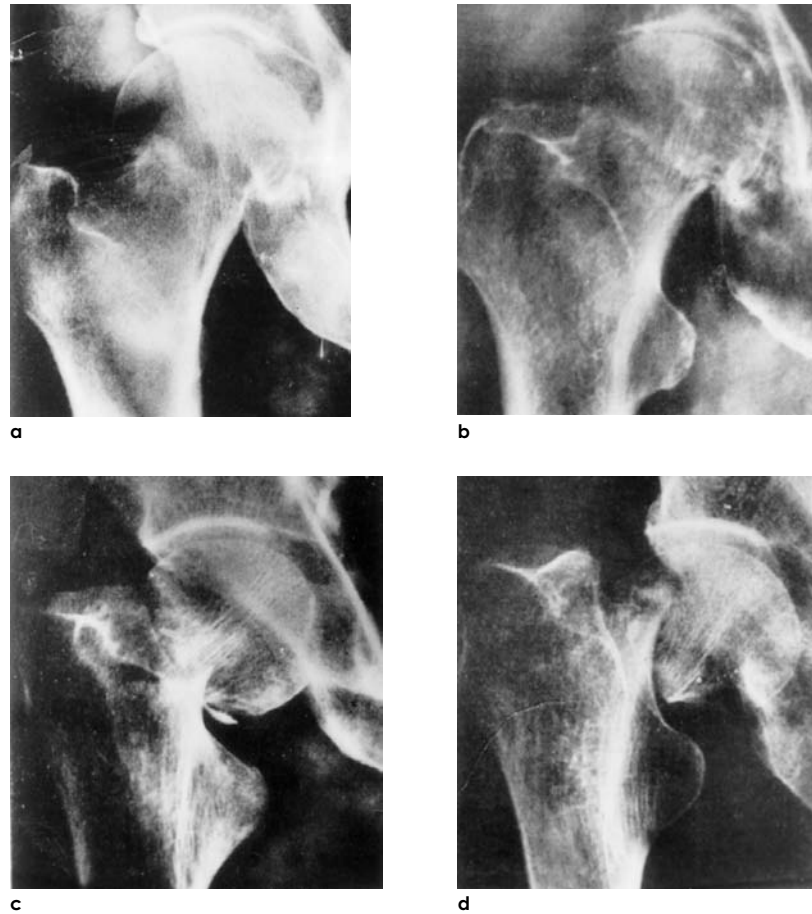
Original radiographs of the four types of Garden classification (1961b). a. Garden-I; b. Garden-II; c. Garden-III; d. Garden-IV
